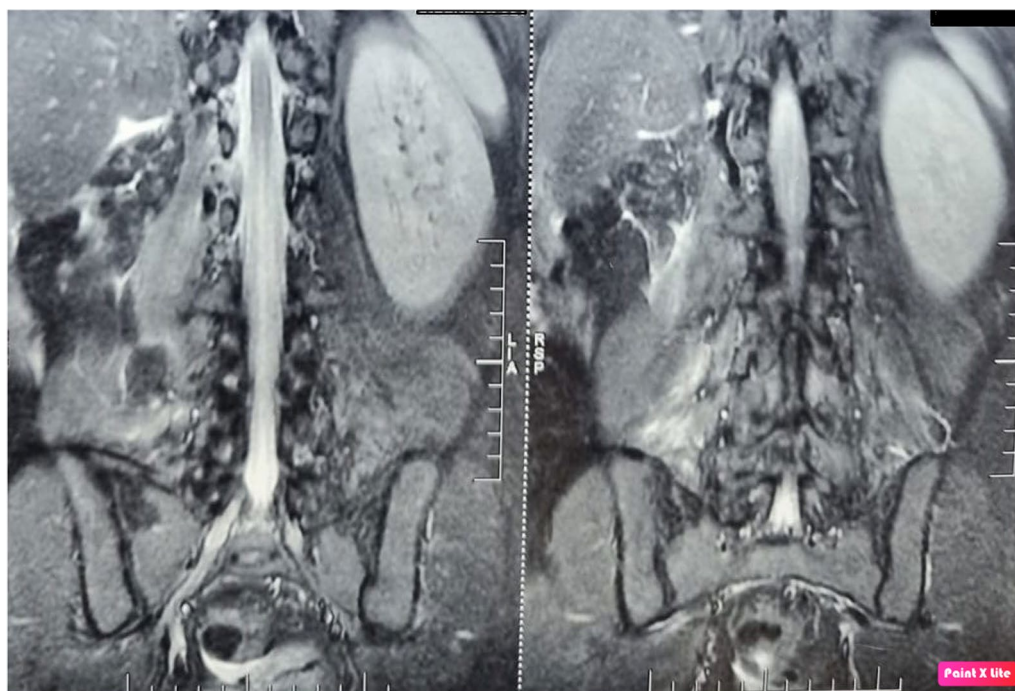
Follow-up MRI image at 6 months showing no evidence of recurrence
